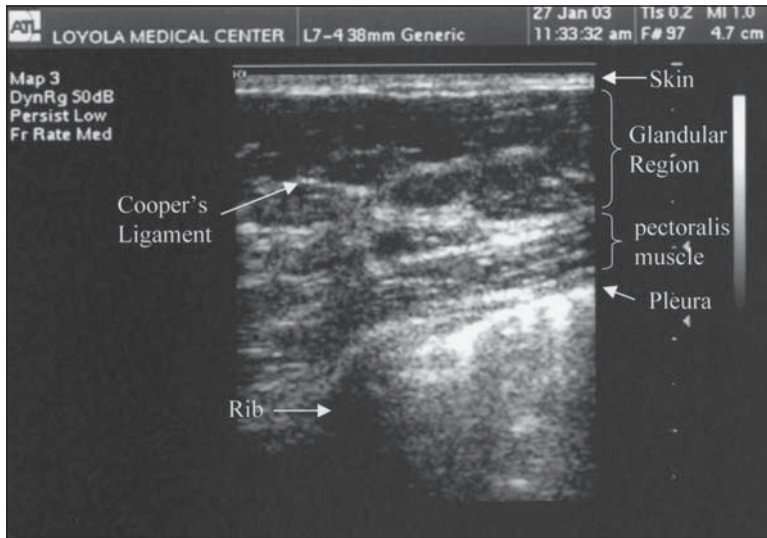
Breast sonogram.
